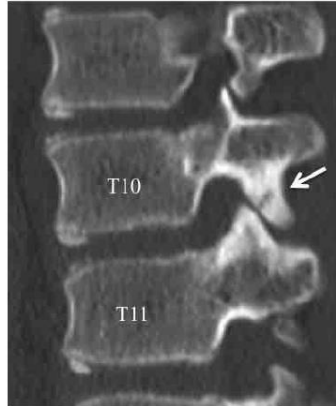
Right parasagittal multi-planar reconstruction CT images showing a fracture line at the right inferior articular process of the T10 vertebrae.
